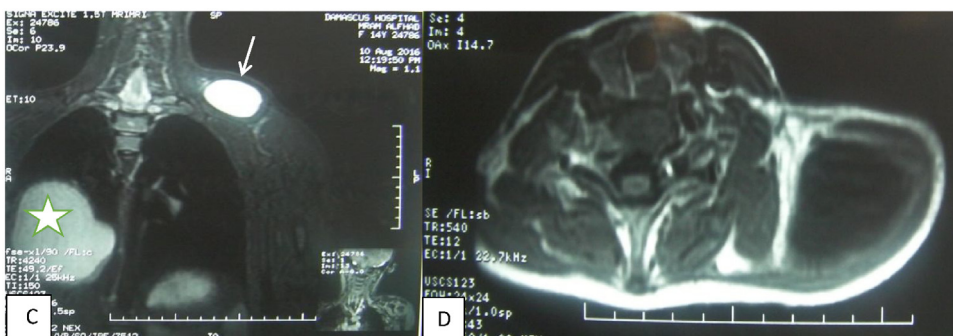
Chest MRI: C: T2 weighted image(coronal section) shows two high sign intensity cystic lesions, one 5.5*4.5 cm within the thickness of left trapezius muscle(white arrow) and the other 10*8 cm in the right lower lobe of the lung(white star). D: T1 weighted image(axial section) reveals low sign intensity cystic lesion within left trapezius muscle.
